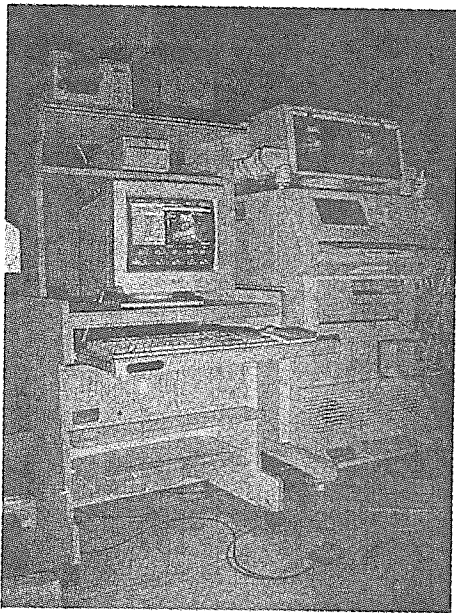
The image acquisition station of the UIAS (arrow) for inpatient ultrasound scanner, with a pedal switching plate (small arrow) for image capturing and multi-format camera exposure.
